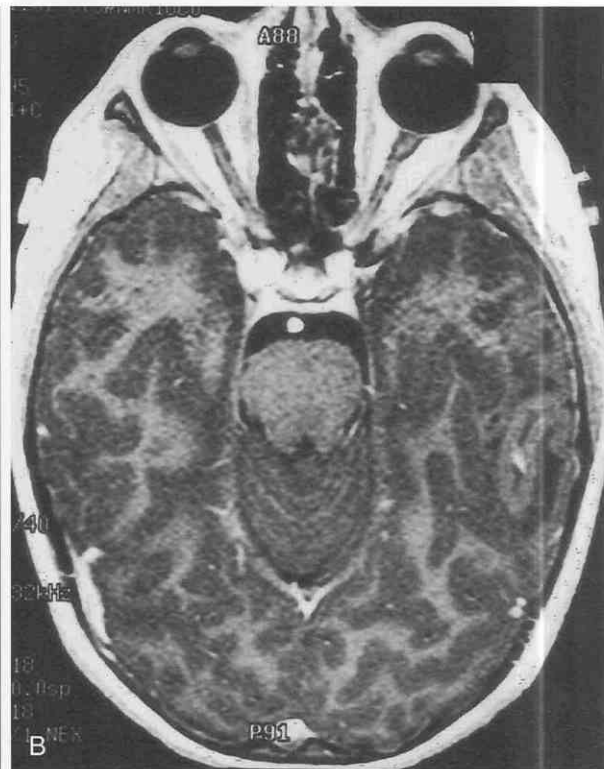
Meningioangiomas. A, Axial T2-weighted image reveals left temporal gyriform hypointensity with subcortical hyperintensity (arrows) that may represent the meningo-vascular proliferation. B, This axial spoiled GRASS image does not reveal enhancement. GRASS, gradient-recalled acquisition in a steady state.
